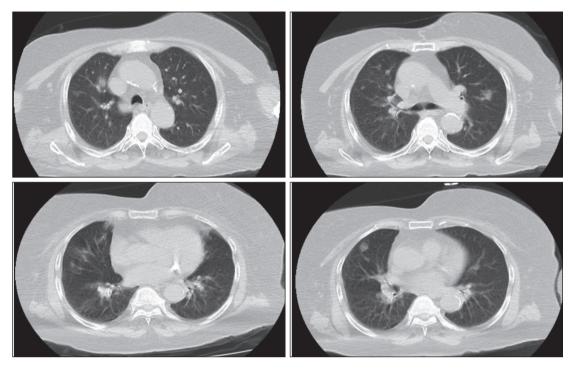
Thorax CT images of the patient.
